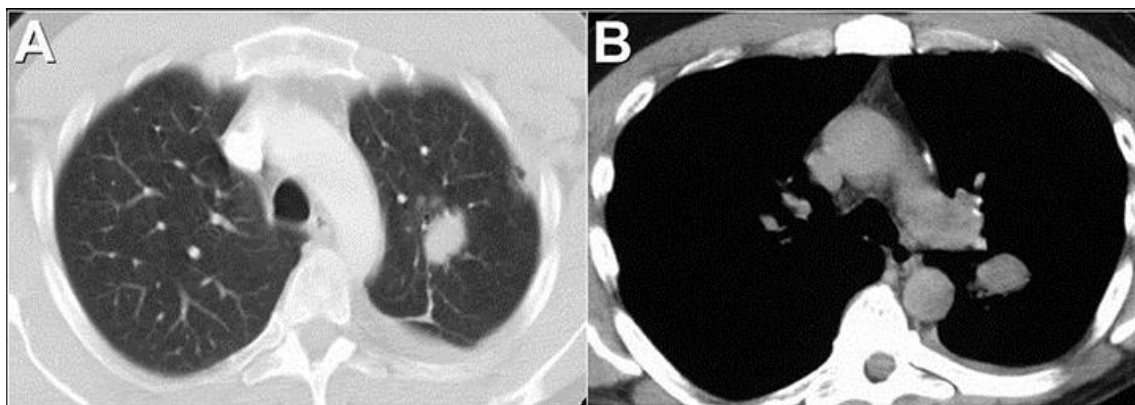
Axial enhanced thoracic CT through the level of the aortic arch (A) displayed in lung windows and slightly more caudally, at the level of the left pulmonary artery (B), the latter displayed in soft tissue windows.
